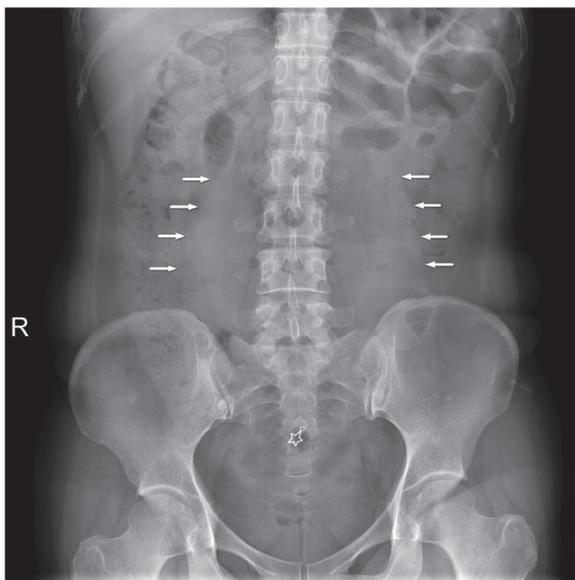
Plain abdominal radiographs showing asymmetric psoas lines (arrows).
